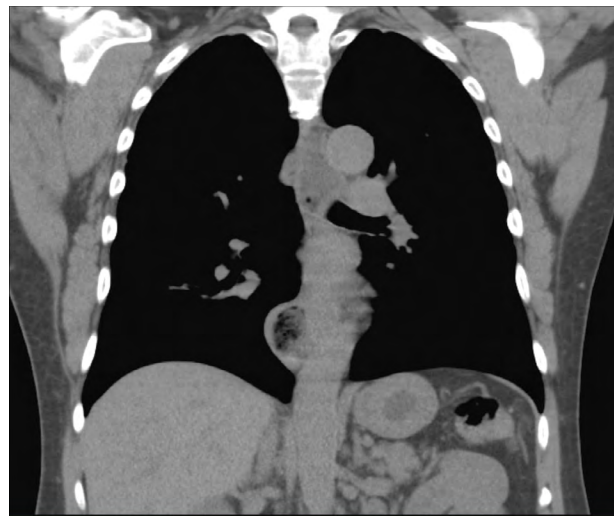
Coronal view of the non-contrast chest CT scan significant for esophageal wall thickening and diverticulum with air-fluid levels in distal esophagus.
